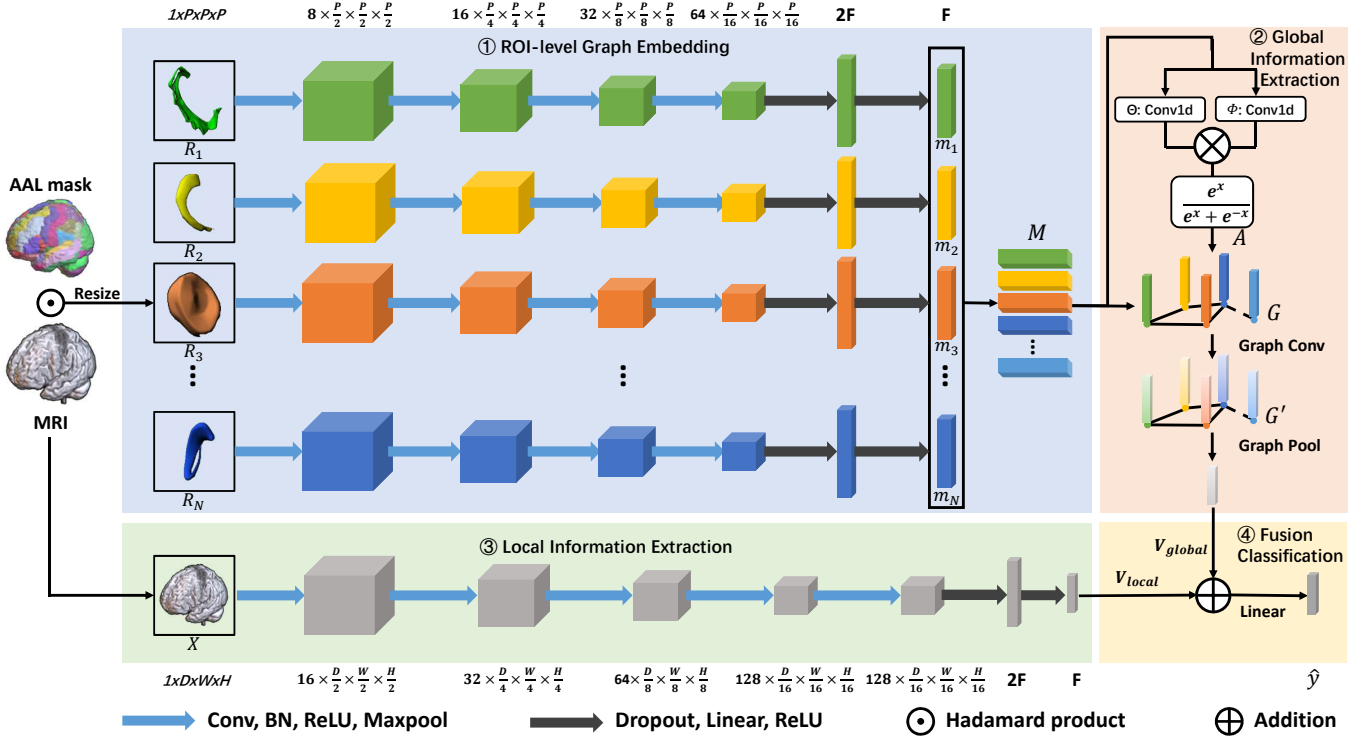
The framework of the proposed BGL-Net method. It contains four blocks, 1. ROI-level Graph Embedding: AAL atlas is used to segment MRI into different brain regions, and extract the node features of each brain region through a series weight-shared graph embedding network; 2. Global Information Extraction: transform those ROI-level node features into a graph representation through the proposed adaptive graph generation module (GGM), and further capture the global information between different brain regions through graph convolution to obtain advanced classification features; 3. Local Information Extraction: CNN is used to extract features of the entire MRI and obtain advanced classification features focused on local information due to the locality of the convolution operation. 4. Fusion Classification: Fusion classification of the advanced classification features of the global and local information to obtain the diagnosis result.
